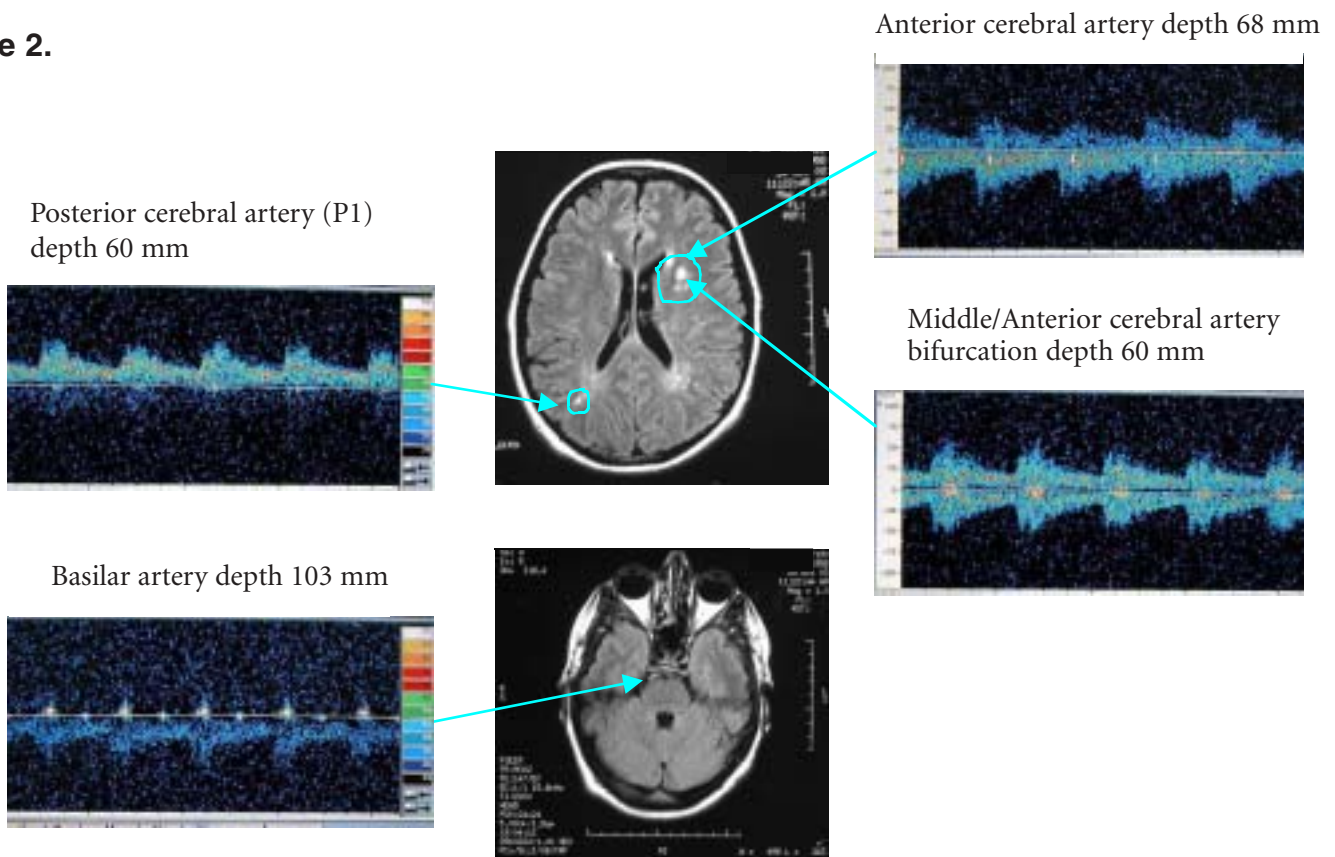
Knock is shown at peak systole in the anterior cerebral artery (top right) and Posterior cerebral artery (top left). A bruit was found at the MCA/ACA junction (middle right). This was associated with hyperintense areas on FLAIR MRI (middle top). SVK was found in the Basilar (bottom left). The brain stem was normal (middle bottom).
